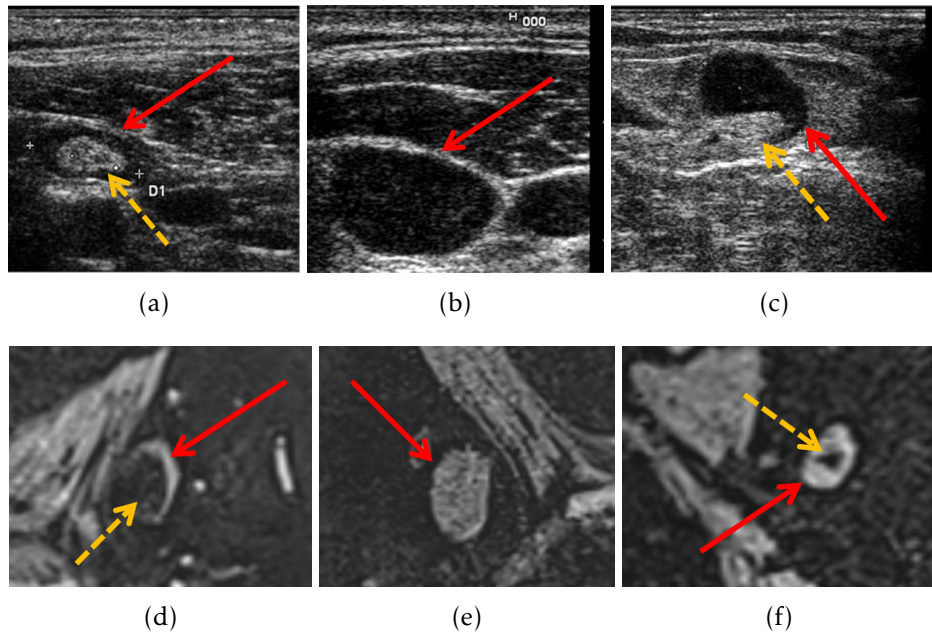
Examples of lymph nodes (red arrows) in (a,b,c) Ultrasound [10] and (d,e,f) T1-weighted with fat suppression MR images. Healthy lymph nodes with a fatty hilum (dashed yellow arrows) are shown in (a) and (d), metastasised lymph nodes without hilum are shown in (b) and (e), and round-shaped metastasised lymph nodes with hilum (dashed yellow arrows) and increased cortex thickness are shown in (c) and (f).
